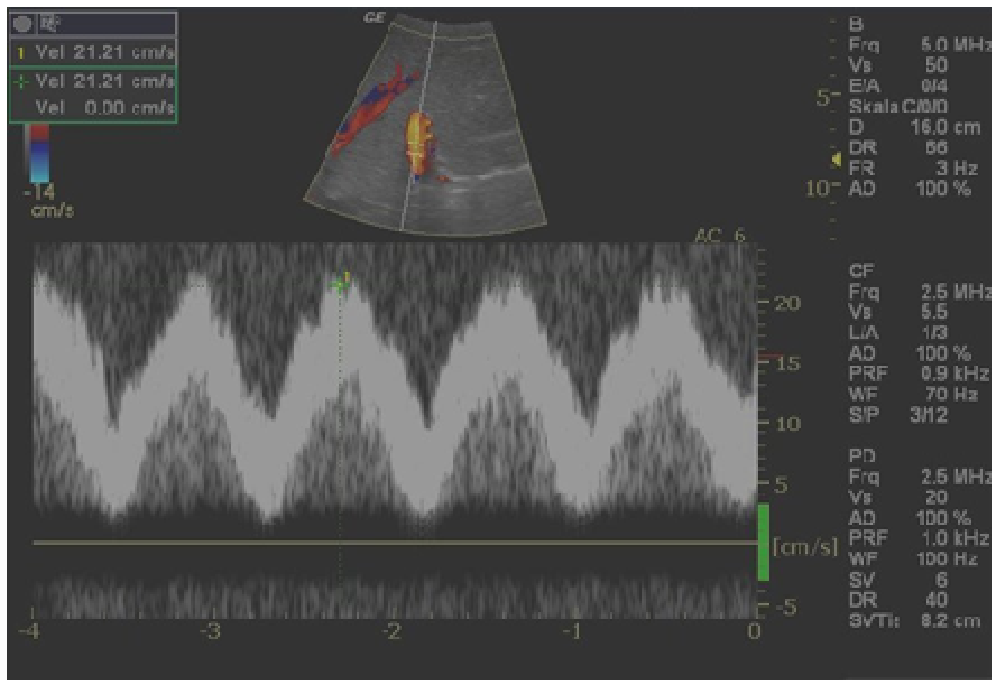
Ultrasound-picture with colour Doppler: Measurement of the portal vein flow
